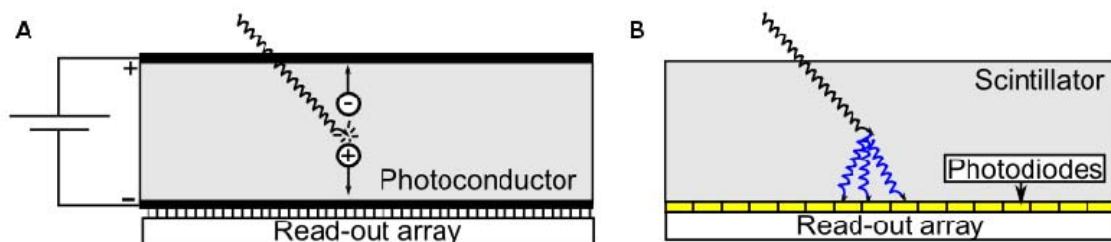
Scheme of direct (A) and indirect (B) detection approaches used in x-ray flat-panel detectors.
